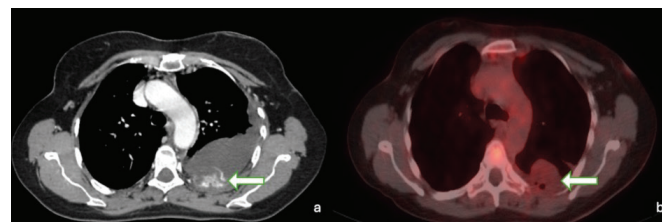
Axial thoracic CT (a), and fused PET-CT (b) images showing a pleural-based lesion (green arrows) adjacent to the left posterior thoracic wall. The lesion is visible on both modalities; however, no significant FDG uptake was detected in PET-CT.
